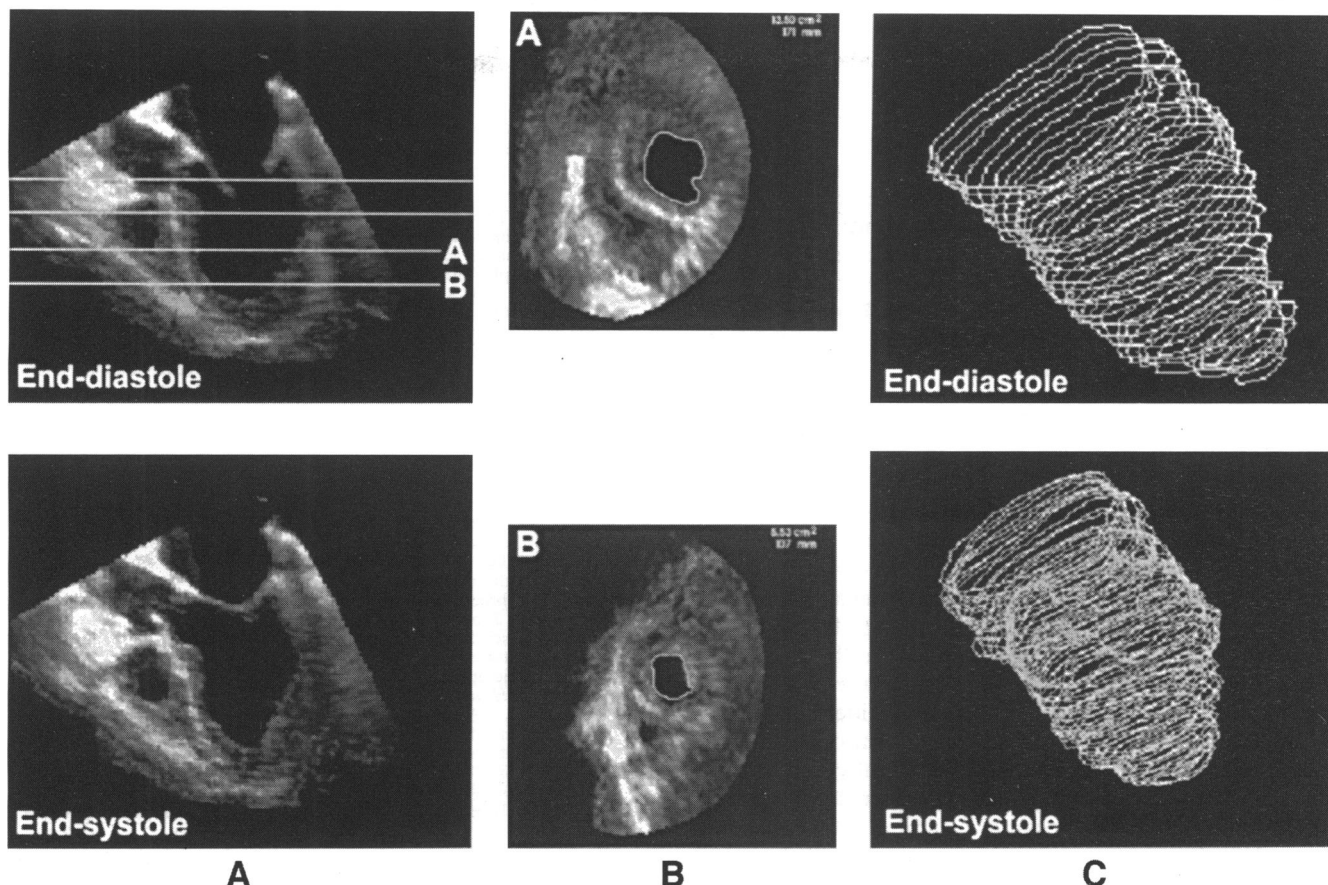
Principle of left ventricular volume calculation using a three-dimensional data set (paraplane echocardiography). An end diastolic long axis view is selected as a reference view and the left ventricle is sliced at equidistant intervals to generate a series of short axis views (B). The contours of the left ventricular cavity are planimetered and the volume of each slice is calculated. Adding up the volumes of all slices provides an accurate volume measurement of the left ventricle (Simpson's rule). This is performed for both end diastolic and end systolic data sets. The figure shows an end diastolic long axis view (A) with three lines indicating the short axis views shown in the panels B. Panels C show reconstructions of the left ventricle using the planimetered contours of short axis views obtained every 3 mm.
